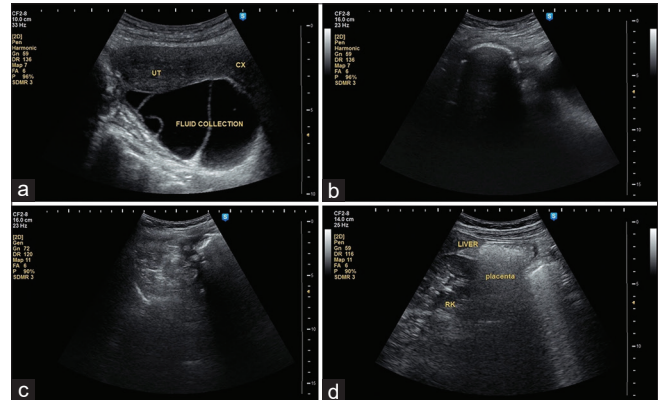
Transabdominal ultrasound showing an (a) empty uterus and the (b, c) extrauterine fetus and (d) placenta at 16 weeks and 3 days age of gestation described as a deformed fetus measuring 10.5 cm in length casting posterior acoustic shadows located at the right upper quadrant, inferomedial to the liver and the placenta located anterior to the fetus and below the anterior abdominal peritoneum and in close proximity to the liver, described as a heterogenous mass measuring 7.0 cm × 1.6 cm
